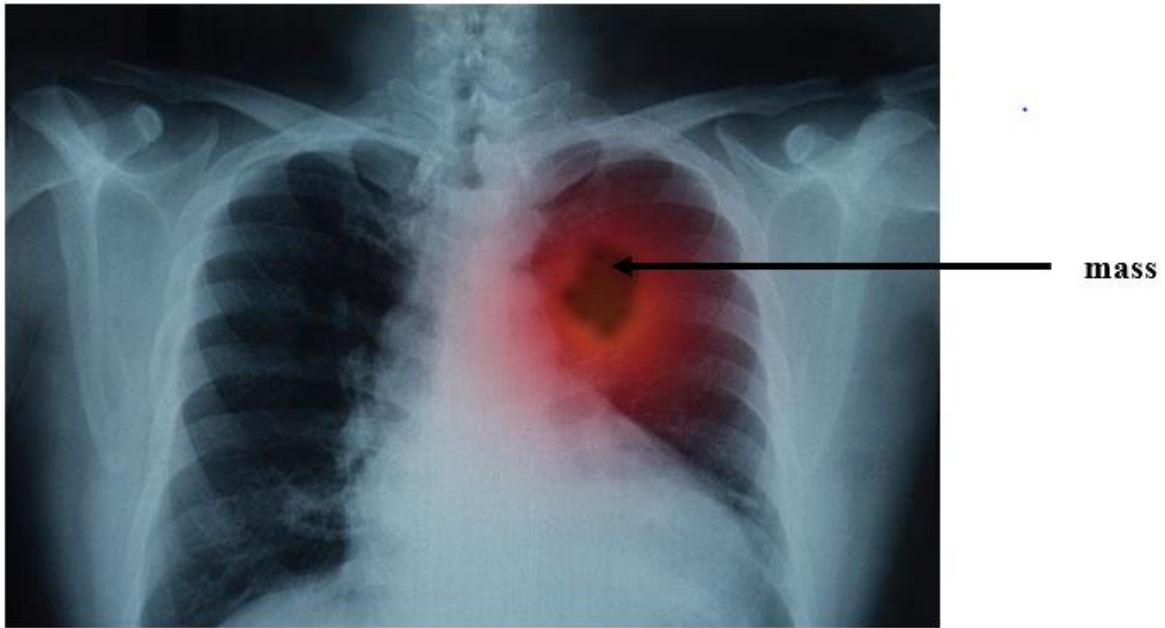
Chest radiography demonstrating a mass [7].
